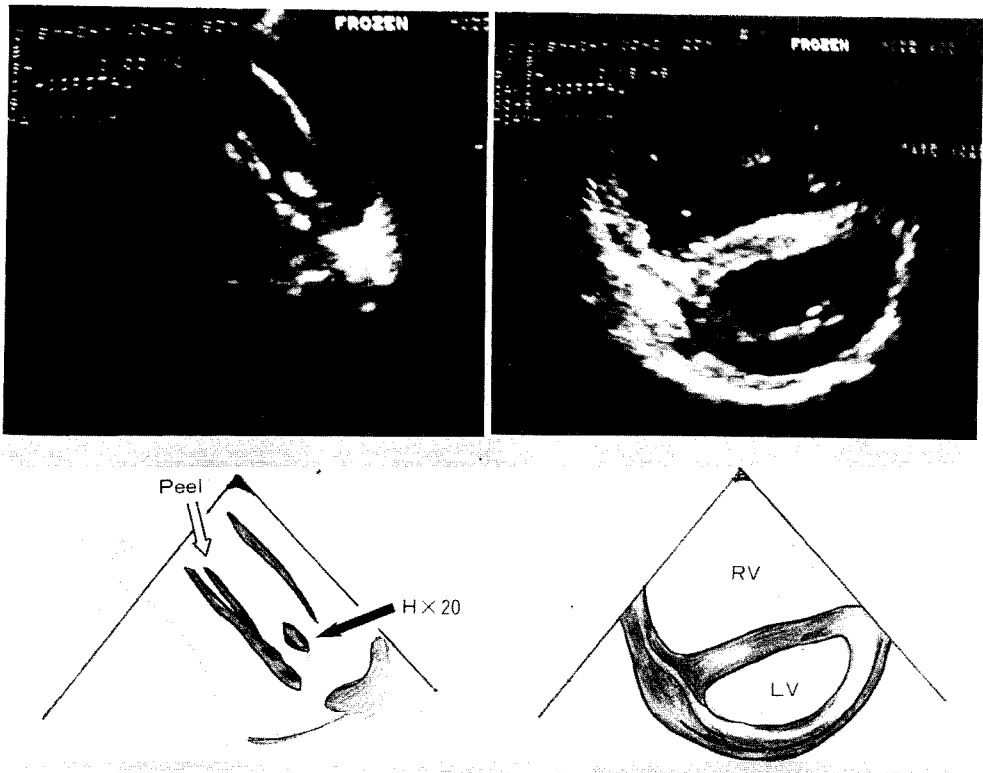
Two-dimensional echocardiogram of case No.14. Hancock valve is fused and calcified but still retains movement. Non-obstructing, neointimal peel is seen proximally in the conduit.
